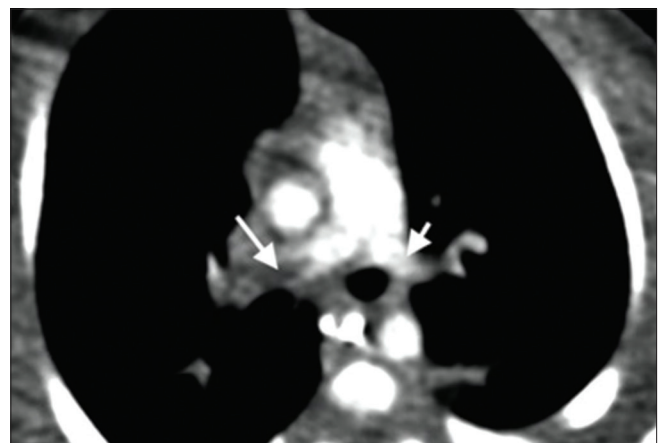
Computed tomography scan of the chest (axial view) showing a large thrombus (long arrow) in the right pulmonary artery and a small thrombus (short arrow) in the left pulmonary artery
